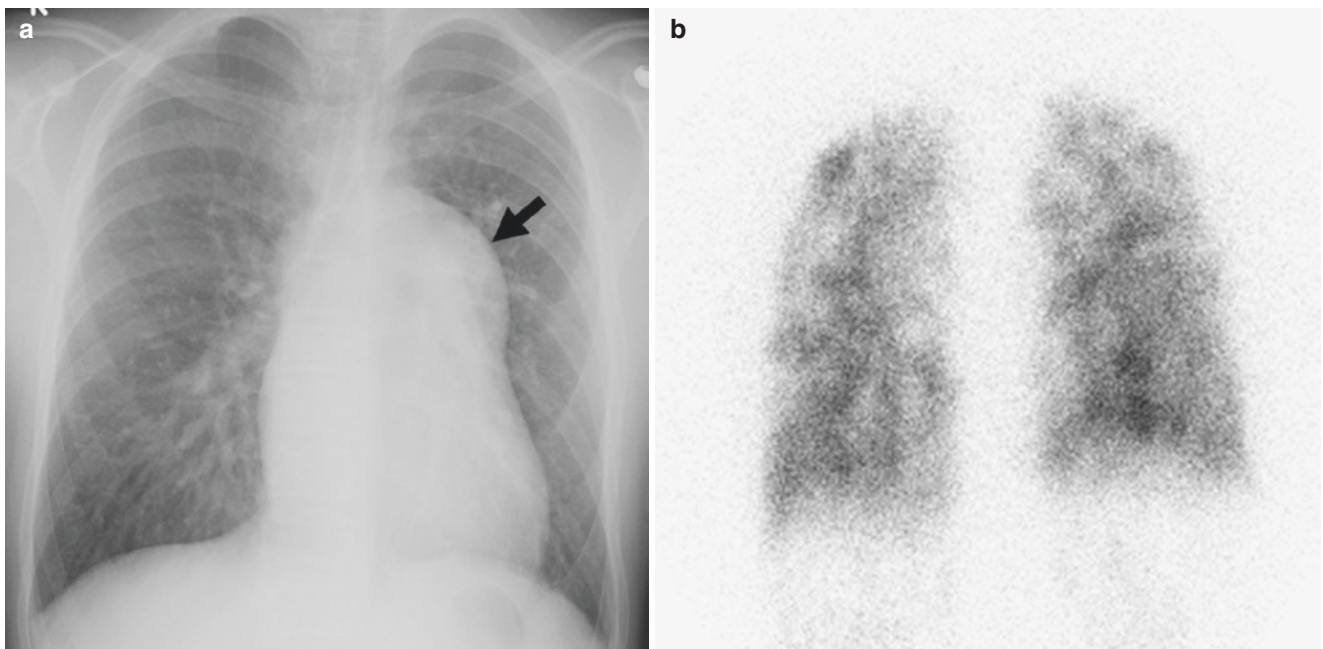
Thirteen-year-old boy with known idiopathic pulmonary hypertension who presented with shortness of breath and decreasing oxygen saturation. V/Q scan was obtained for evaluation of possible pulmonary embolism. (a) Frontal chest radiograph shows a markedly enlarged central pulmonary artery (*arrow*) and cardiomegaly. (b)
